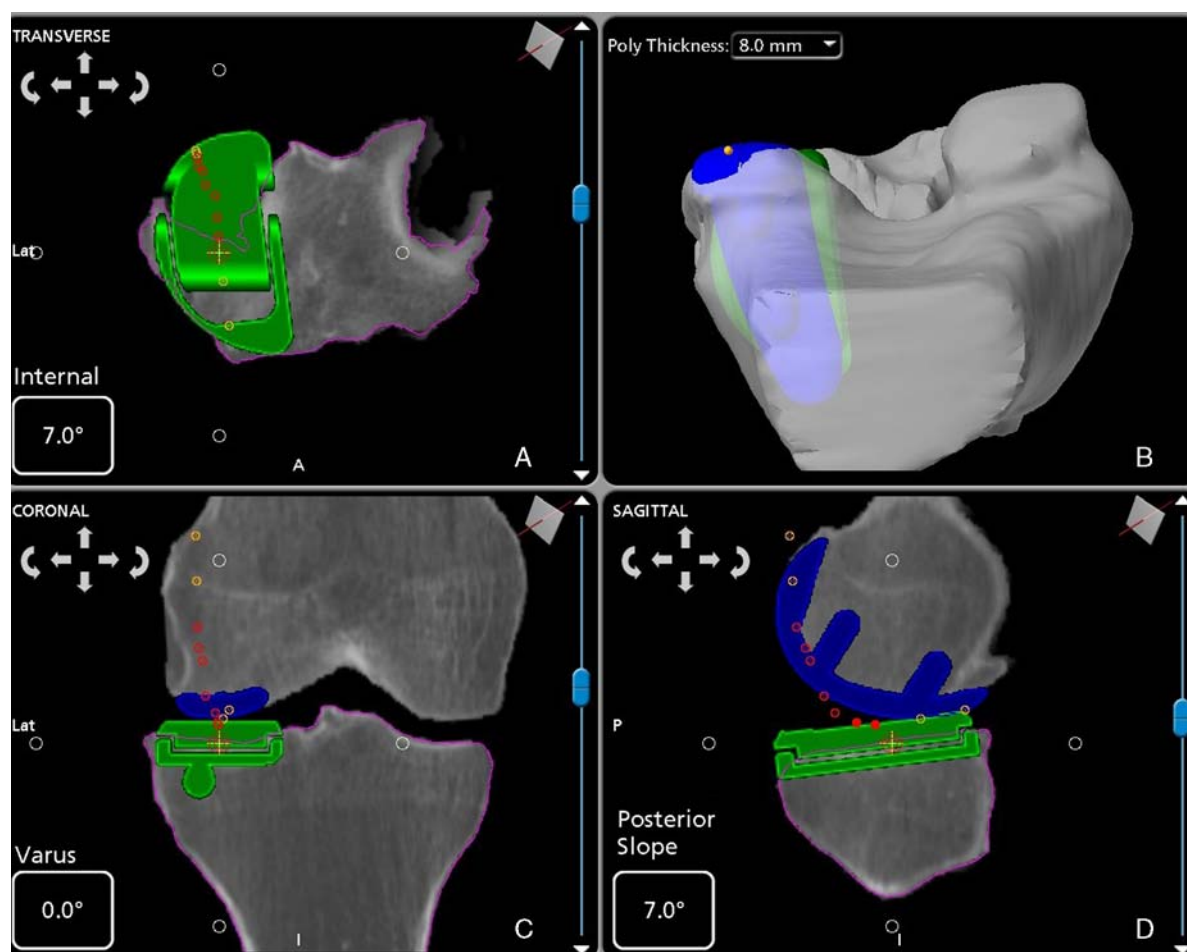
Preoperative templating. All patients undergo CT scanning before surgery. Computer-assisted design models of the implanted components are templated onto the 3D reconstructed images using computer software. A, Axial view of the virtual tibial component on the tibia. The implant is 3 degrees internally rotated relative to the tibia. B, Axial view of the tibial and the femoral virtual components. C, Coronal view of the knee with the virtual implants. The tibial component is in 0.1 degrees of varus related to the tibial axis. D, Sagittal view of the knee with the virtual implants. The tibial component has 5 degrees of posterior slope related to the axis of the tibia.
